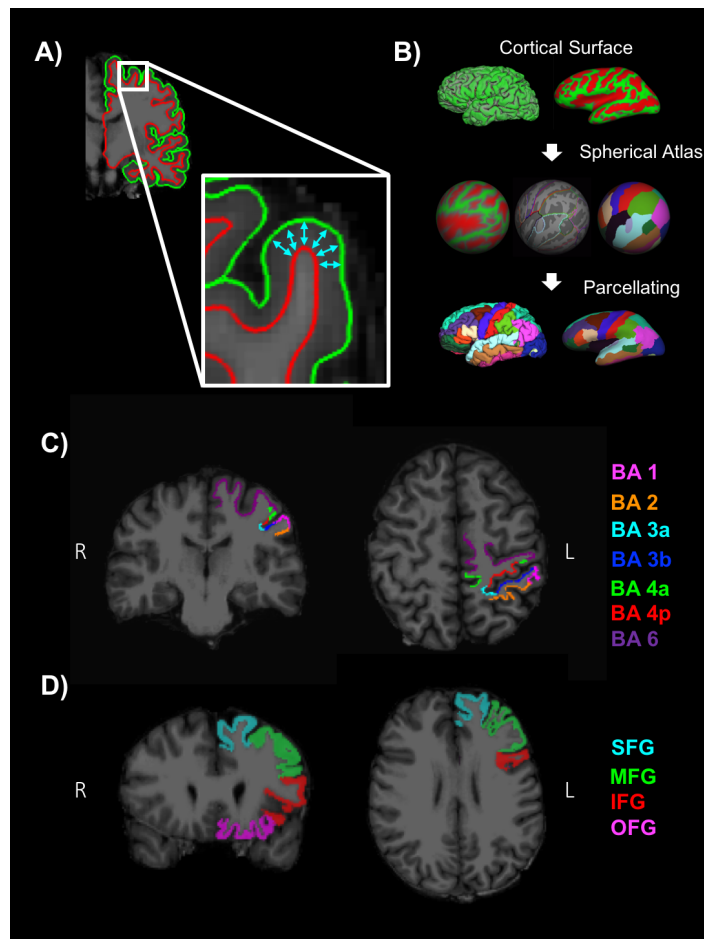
A) Depiction of the pial (green) and WM (red) boundary. CT is measured between these boundaries. B) Freesurfer determines regions by parcellating the cortical surface model using a spherical atlas. C) Example of sensorimotor and frontal reference D) ROIs used for CT analysis.
